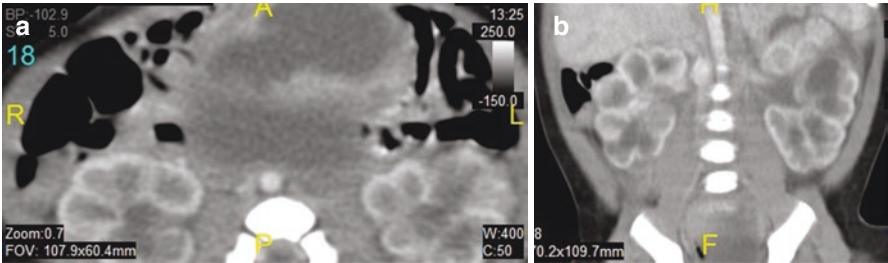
(a and b) Abdominal CT-scan showing bilateral hydronephrosis secondary to pressure from hydrometrocolpos
